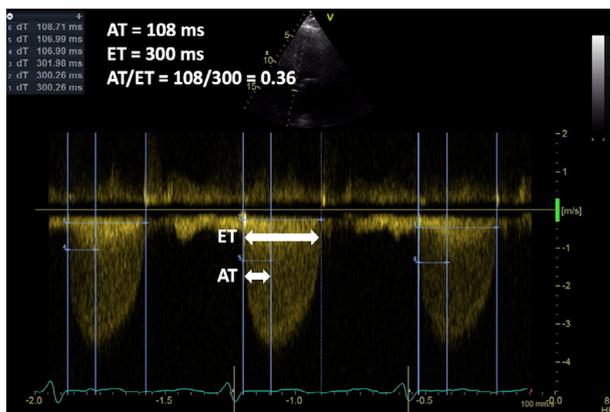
Systolic time interval measurement on a continuous-wave Doppler recording of transaortic flow. AT = Acceleration Time, ET = Ejection Time
